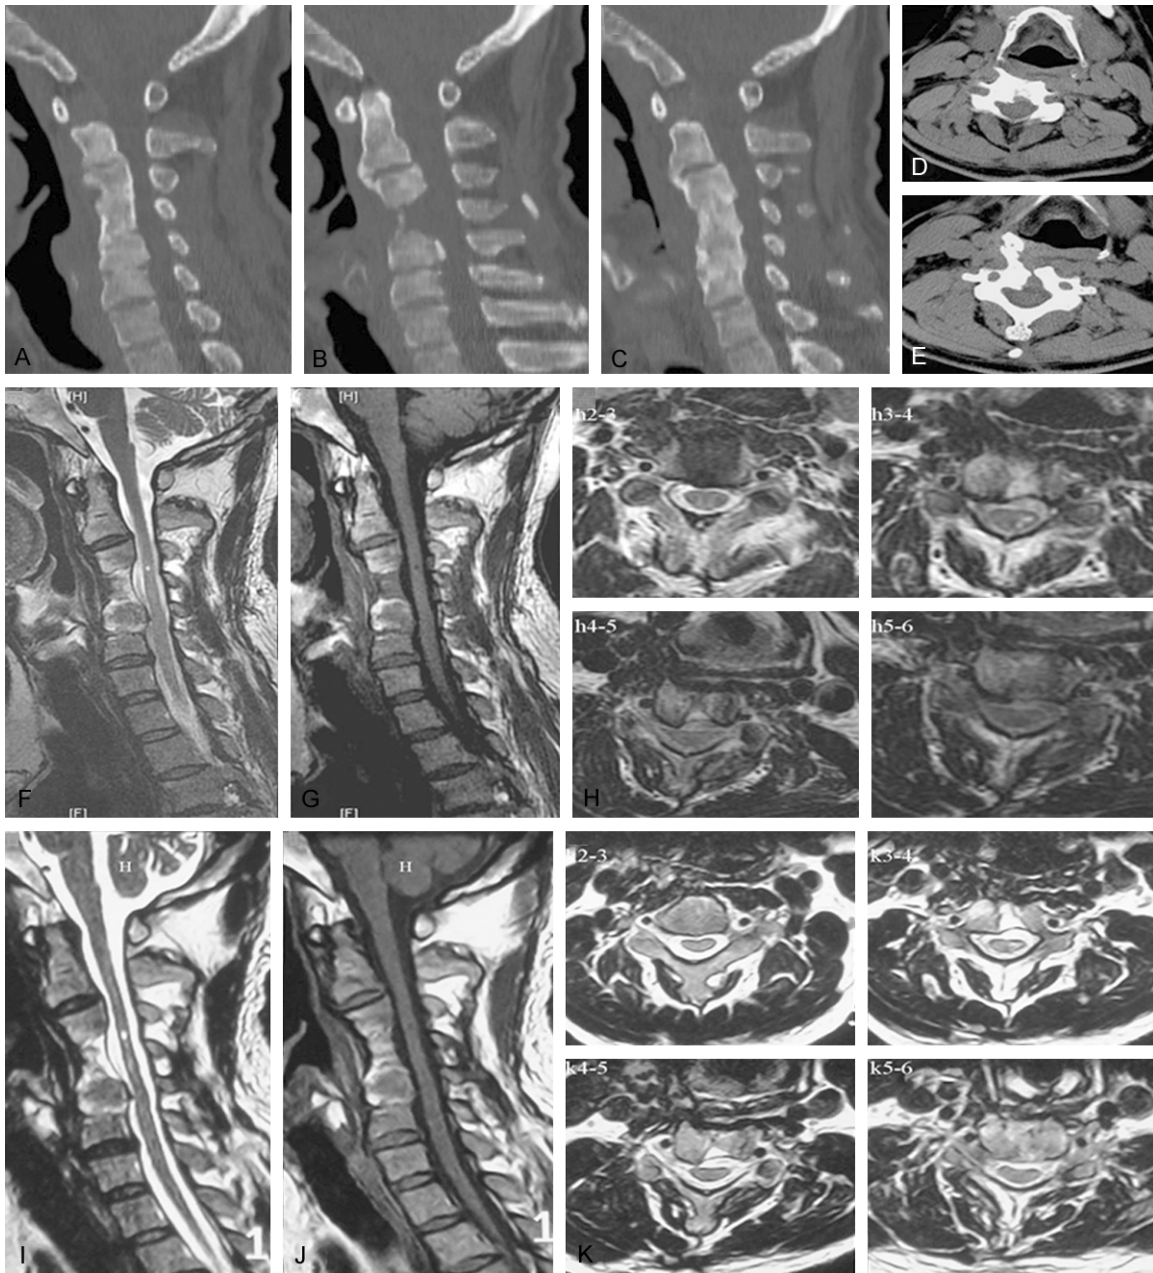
Follow-up results 7 months and 2 years after internal fixation removal. A-E: The CT review 7 months after internal fixation removal showed that the cervical lordotic curves in the operative region were lost, but osseous fusion was achieved at both sides of the operated segment. F-H: MRI did not show apparent spinal cord compression; the T2 weighted image exhibited abnormal hyperintensities in the horizontal cord of C3-4 and the T1 weighted image exhibited hypointensities, suggesting an irreversible damage to the spinal cord. I-K: The MRI review 2 years after the operation showed that although there was no apparent spinal cord compression at the operated segment, the abnormal signals in the horizontal spinal cord of C3-4 still existed.
